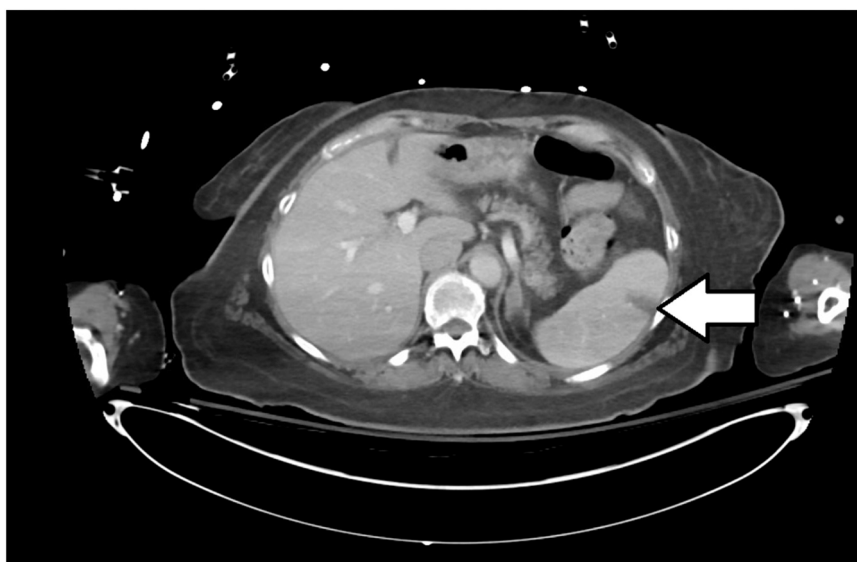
Abdominal CT, arrow showing splenic infarction.
